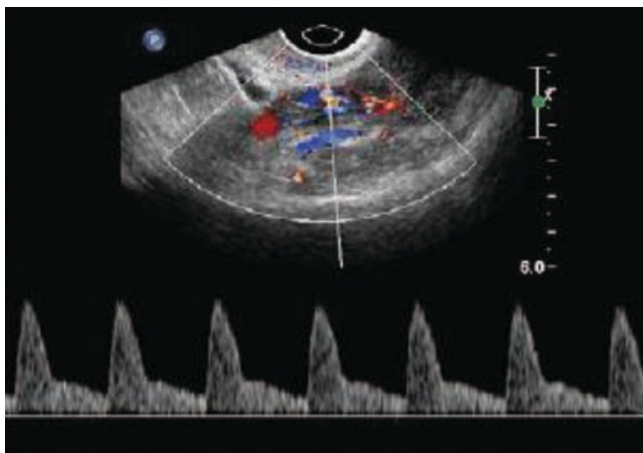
Color Doppler spectrum of the uterine artery during the non-pregnant period
